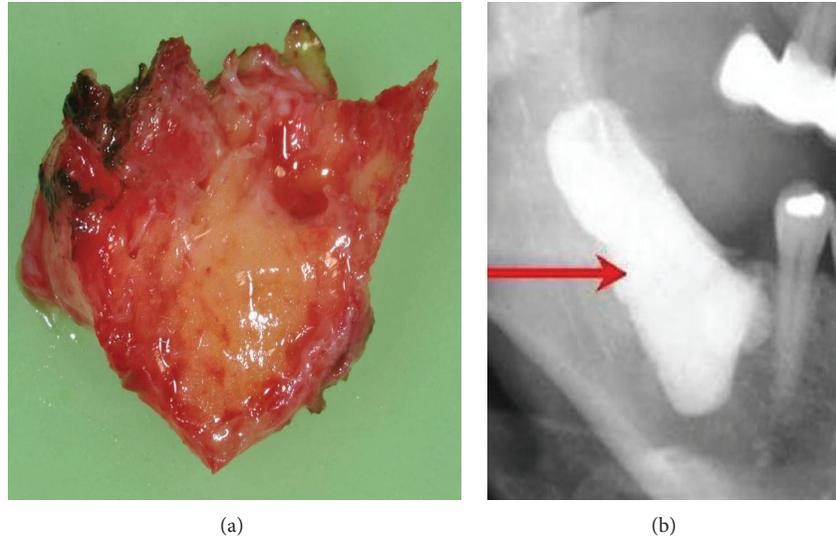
FDOJ sample of fatty and osteolytic degenerated bone marrow (a) and contrast medium X-ray of the FDOJ cavity after curettage (b).
